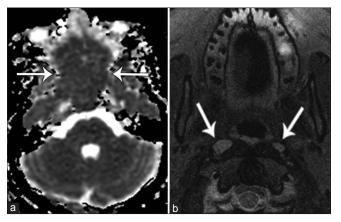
MR images important for the correct differential diagnosis: ADC map (a) demonstrating mild restricted-diffusion, suggesting hypercellularity. Axial T2 (b) at the level of the nasopharynx demonstrates enlarged retropharyngeal lymph nodes, suggesting either primary lymphoid-disease or typical nodal spread of esthesioneuroblastoma
